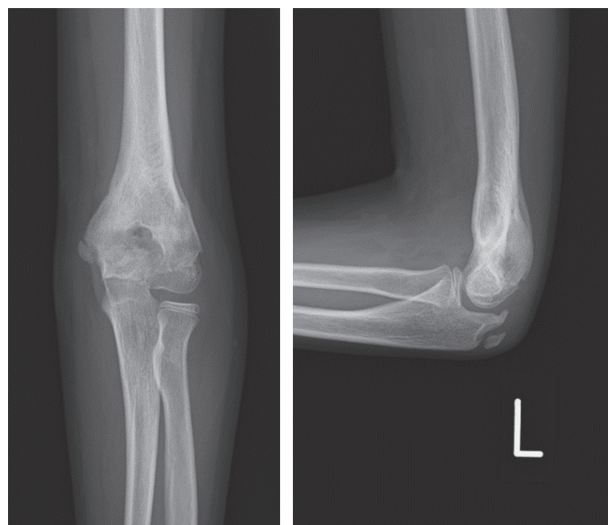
Plain X-ray findings at 14 months after surgery
